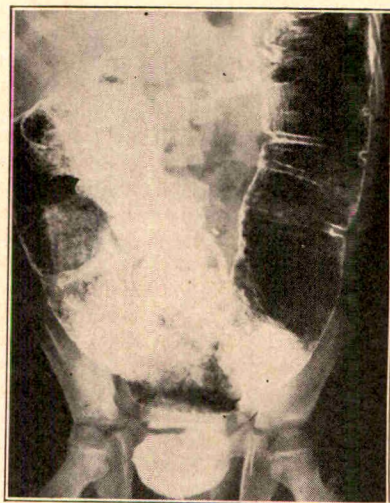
(case 17).—Megacolon with normal rectum and a normal lower segment of sigmoid colon in a 10 year old patient. A sympathectomy performed fifteen days before the roentgenogram was made had partially reduced the size of the megacolon. Episodes of severe distention one year later led to a one stage resection of the megacolon.
